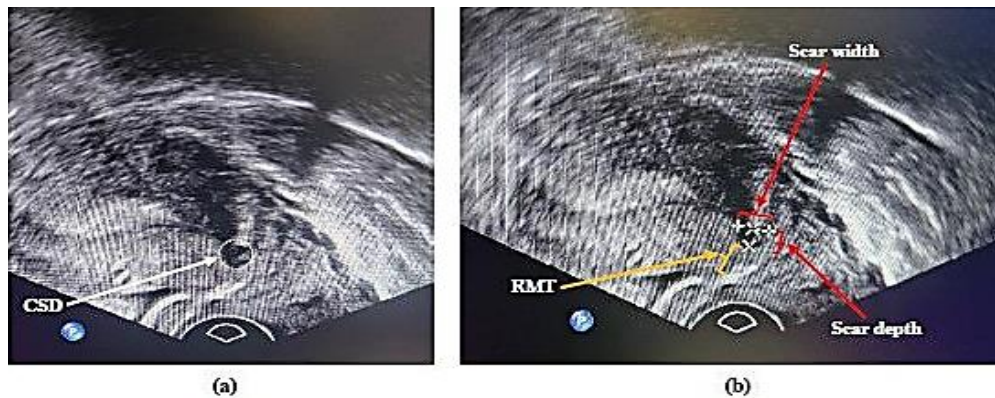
Transvaginal ultrasonographic view of (a) CSD, and (b) measurement of the RMT, scar width, and scar depth
